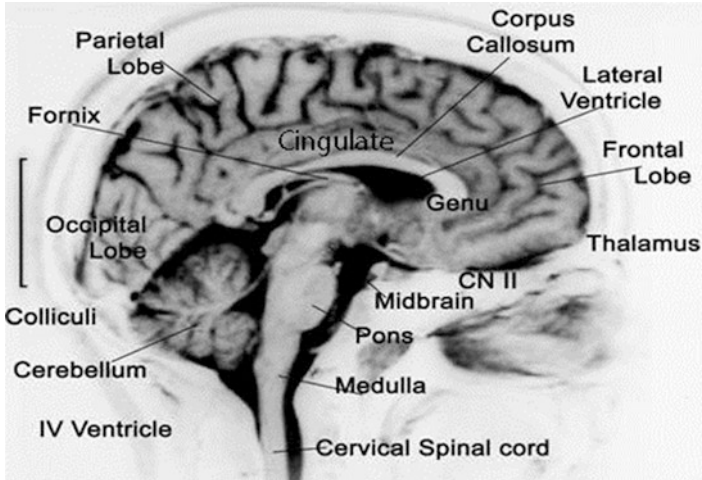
The brain. MRI sagittal plain T2
